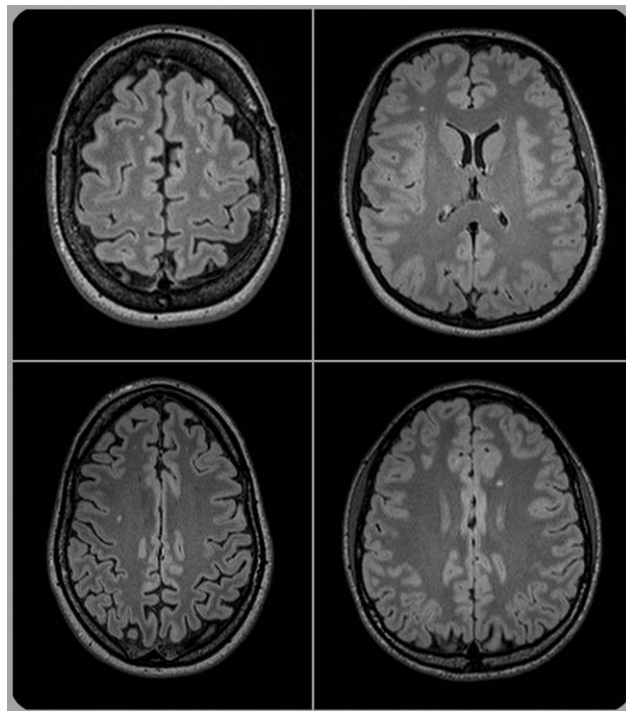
T1w and T2w 1mm isotropic structural imaging. Exemplary 3-dimensional axial fluid attenuated inversion recovery (resolution $1 \times 1 \times 1 \text{ mm}^3$) magnetic resonance images show small white matter lesions in 2 patients (upper row) and 2 controls (lower row).
